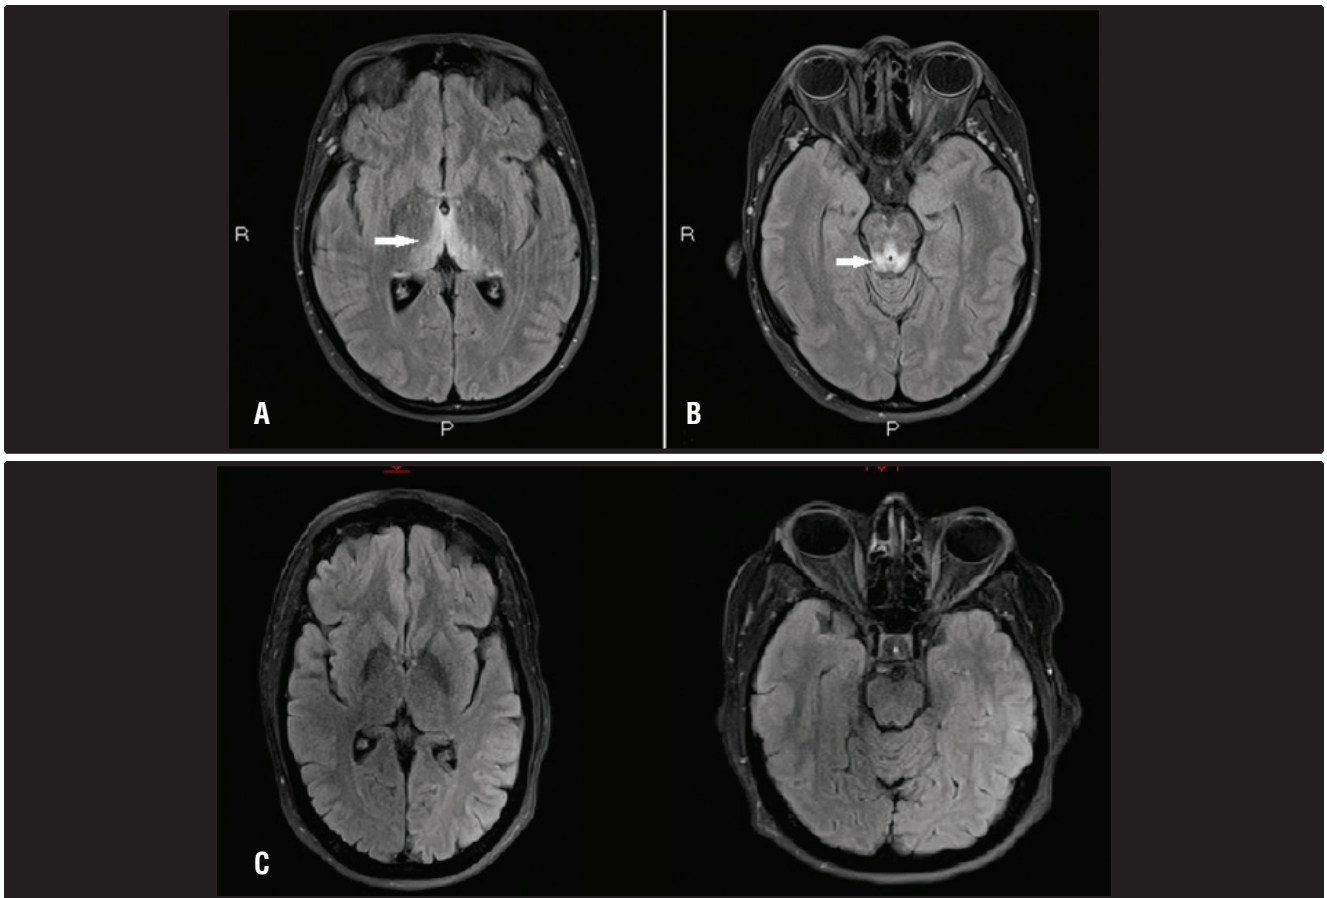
A. MRI brain image of a Fluid Attenuation Inversion Recovery (FLAIR) sequence from the case presented demonstrating bilateral medial thalamic hyper-intensities as demarcated by the solid white arrow. These are typical findings seen in Wernicke's encephalopathy. B. This again is a FLAIR sequence from the same patient. In this image, the solid arrow points to hyperintensities in the periaqueductal gray matter. C. Normal MRI of an age matched patient for comparison.
